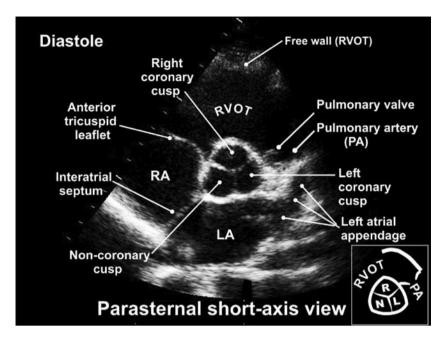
Annotated parasternal short-axis view: aortic valve level (PSAX).
